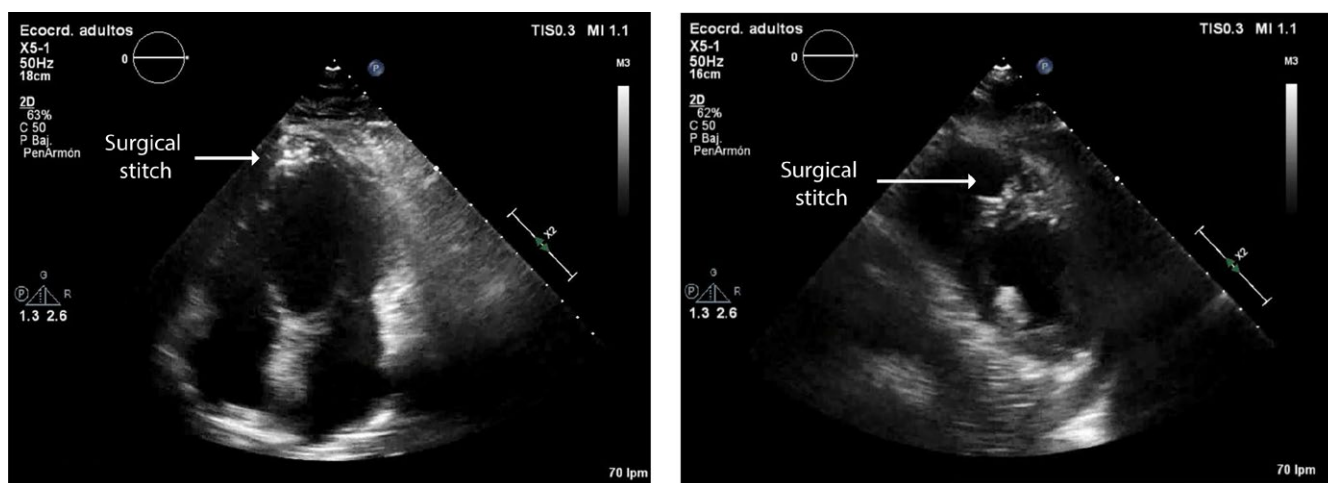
Six-month postoperative two-dimensional transthoracic echocardiogram (2DTTE) showing final left ventricle shape and dimensions
